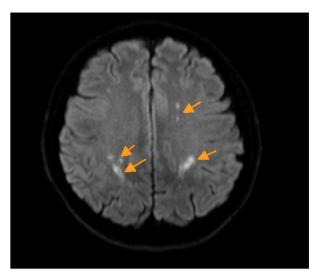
Axial plane of magnetic resonance imaging of the brain showing restricted diffusion in the bilateral centrum semiovale, corona radiata, white matter of the bifrontal and parietal lobes, and bilateral peritrigonal areas, suggestive of acute infarcts (orange arrows).
